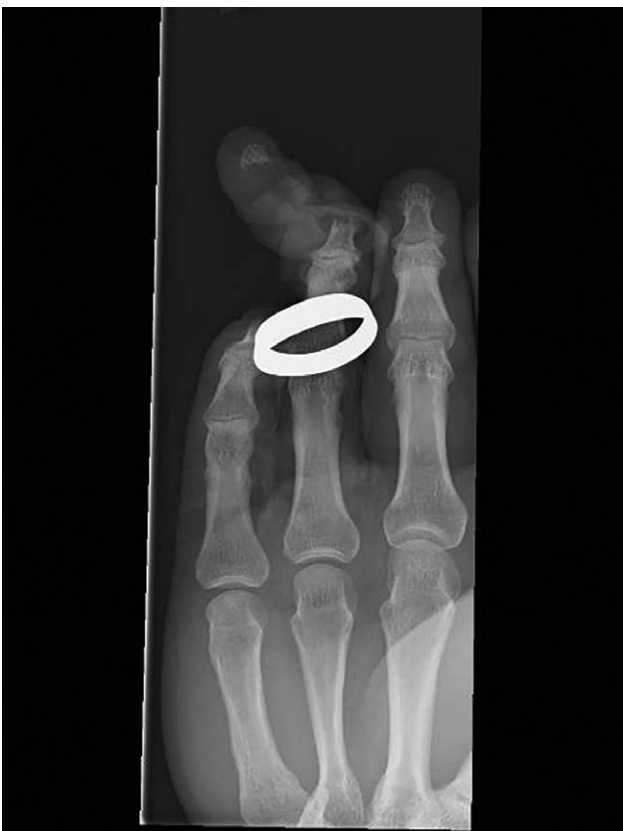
Anterior posterior radiograph of ring avulsion revealing a distal tuft fracture.
